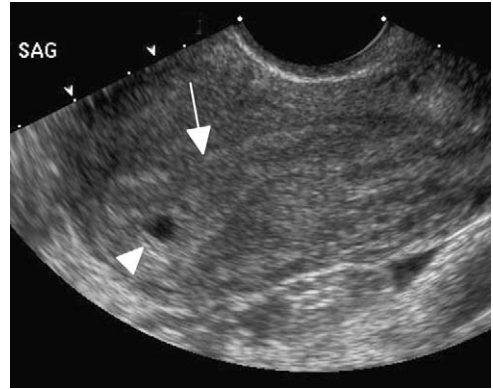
Intradecidual sac sign. Transvaginal ultrasound of the uterus shows a small, round anechoic fluid collection (arrowhead), eccentrically implanted within the echogenic endometrium (arrow), consistent with a very early intrauterine pregnancy.
